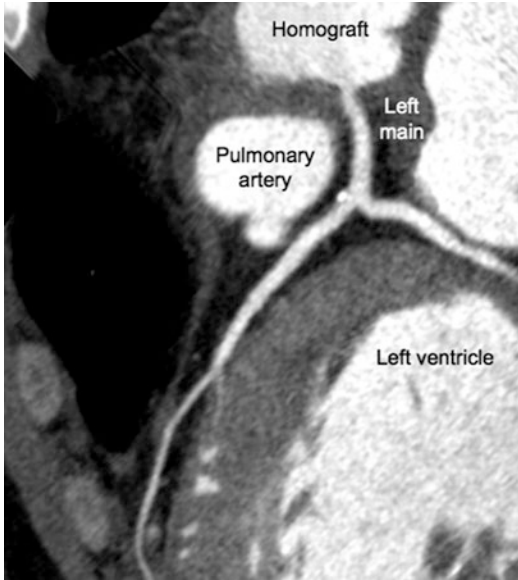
Late postoperative chest computed tomography revealed a patent left coronary artery after homograft root replacement
